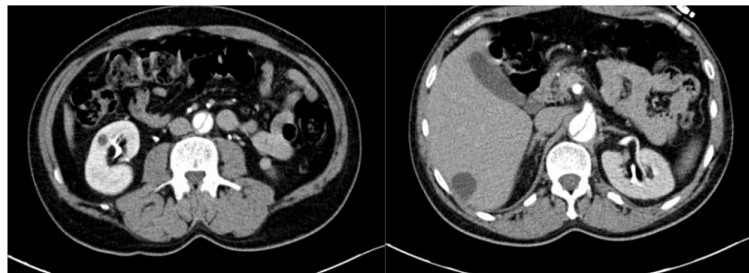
Aortic dissection as seen on axial CT angiogram images.
